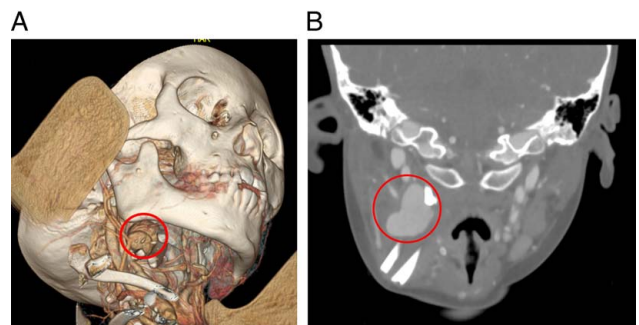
(A, B) Enhanced CT of case 4, with pseudoaneurysms indicated by a red circle. CT indicates computed tomography.
